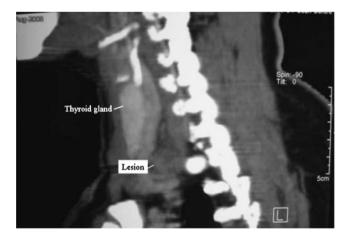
CT scan on sagittal section showing globular lesion below the level of thyroid gland
